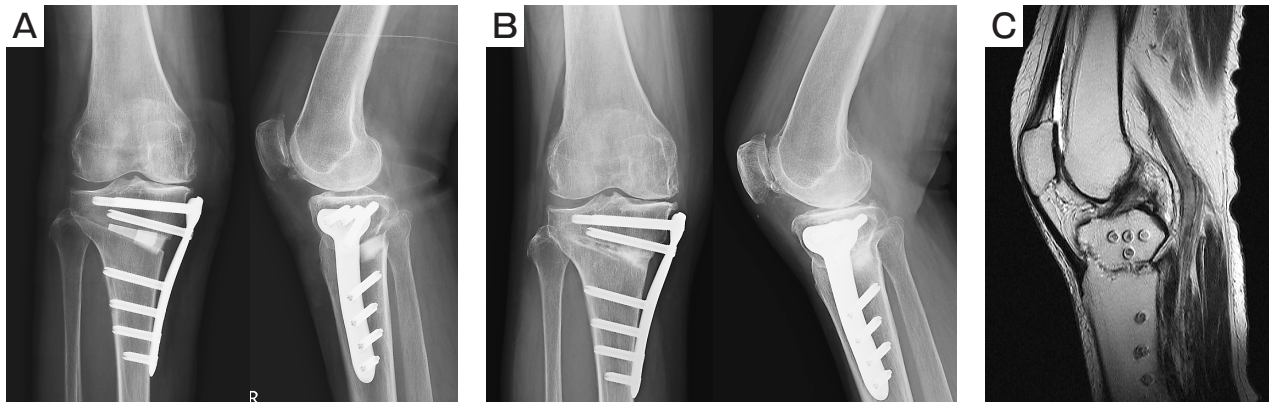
Postoperative radiograph. A, Just after operation; B, One year after operation, bone union had occurred; C, MRI after implant removal.
